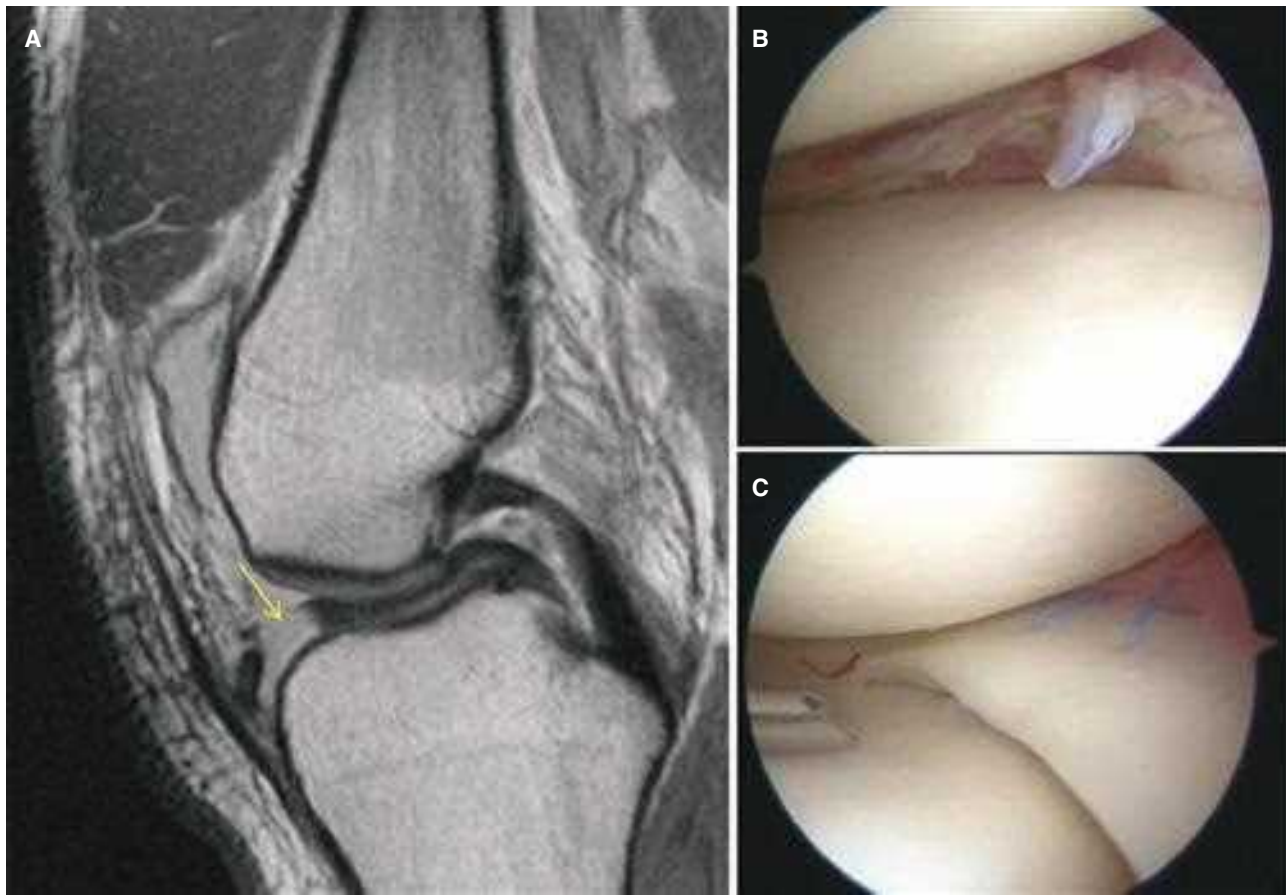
Imaging and treatment of a knee lateral and meniscus tear. A. MRI sagittal T2 image of the knee showing a displaced bucket-handle lateral meniscus tear (arrow). B. Arthroscopic image showing the remnant rim of the lateral meniscus prior to reduction and fixation of the torn bucket-handle fragment. C. Arthroscopic image after the torn segment is reduced and fixed to the remaining meniscus and the lateral capsule using suture.
